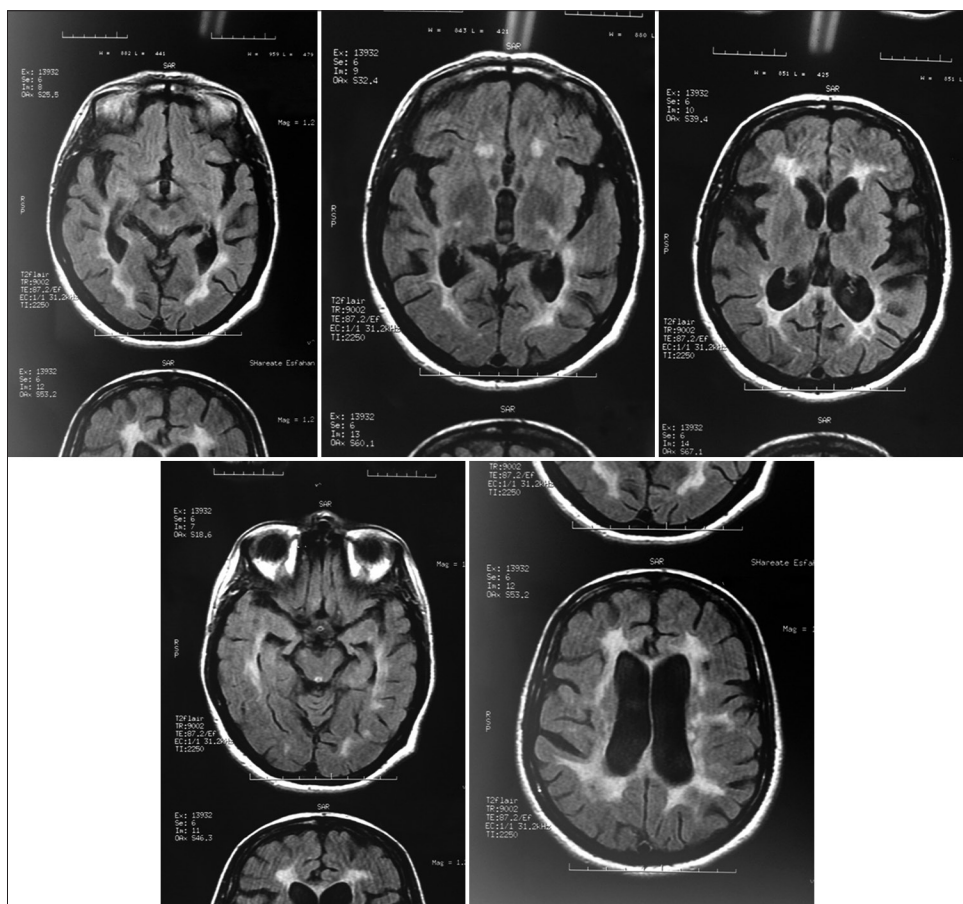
The axial flair MRI of the brain of the patient with periventricular confluent hyper signal plaques
